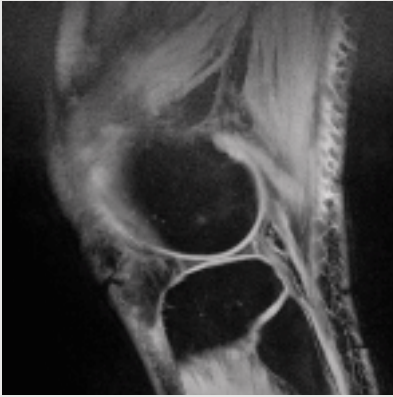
T2-weighted DESS 3D (sagittal), TR: 21.4 ms, TE: 8 ms, slice thickness: 1.8 mm, matrix: 357 x 384, FoV: 161 x 161 mm, flip angle: 25°, BW: 194 Hz/Px.
